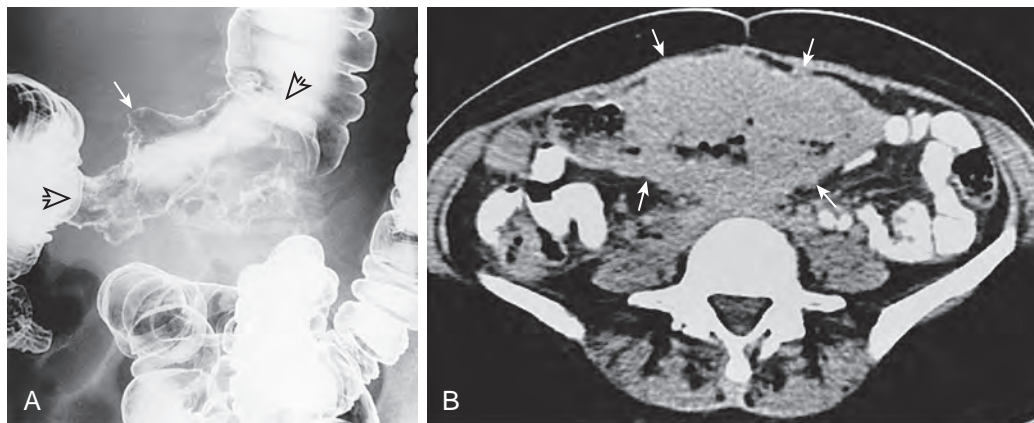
Lymphoma of the transverse colon. A. Spot image from a double-contrast barium enema shows a long (limits denoted by open arrows) concentric lesion in the transverse colon, with an irregular contour. Note protrusion of the contour superiorly outside the expected lumen of the bowel (arrow); this finding indicates cavitation of the mass. B. CT scan shows a large soft tissue mass (arrows) with lobular thickening of the walls of the transverse colon.
